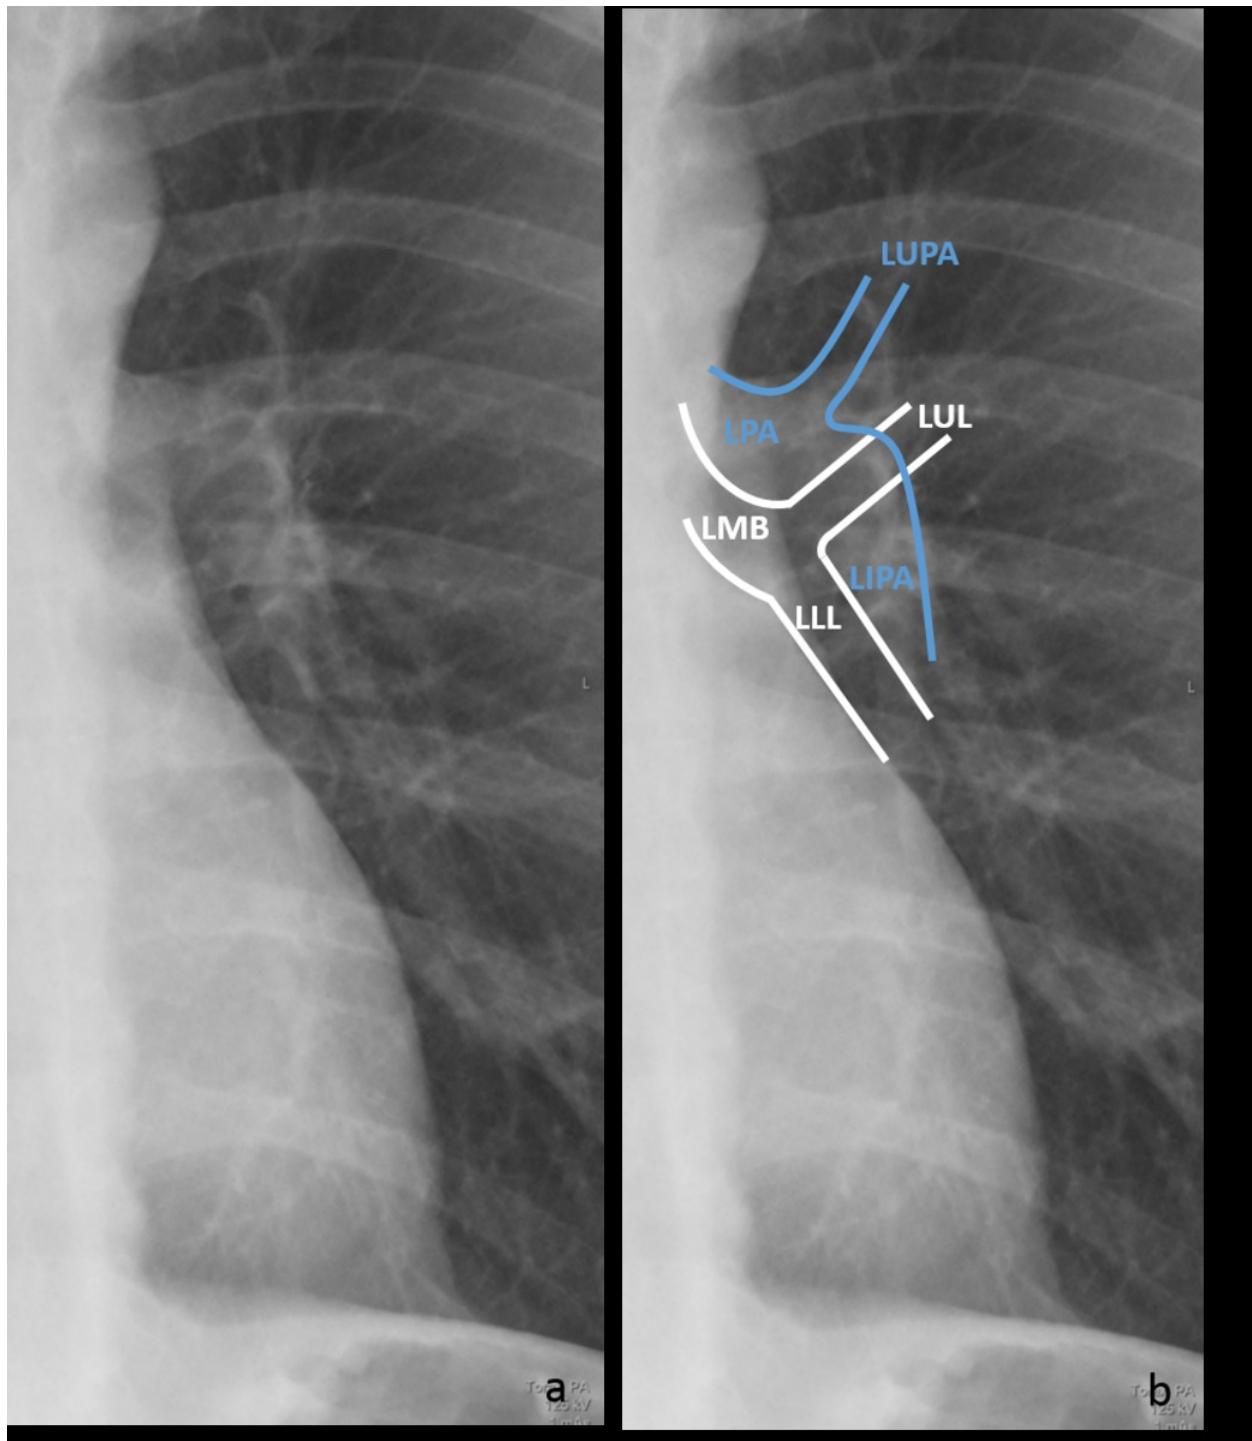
Normal left hilum in a plain radiograph (left) and the corresponding anatomical representation (right). LPA: left pulmonar artery; LUPA: Left upper pulmonar artery; LIPA: Left inferior pulmonar artery; LMB: Left main bronchus; LUL: Left upper lobe bronchus; LLL: Left lower lobe bronchus.
